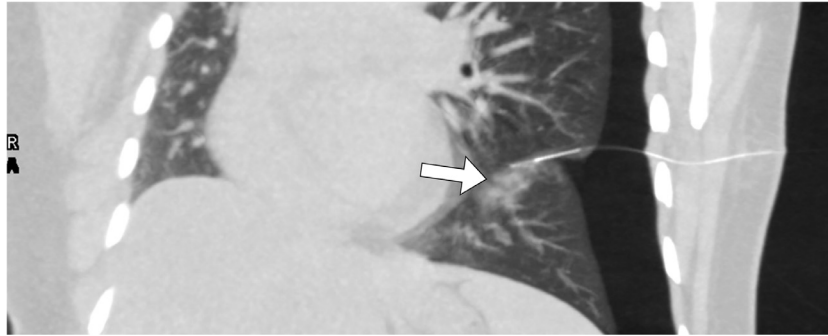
Chest CT scan in sagittal section showing pneumothorax after placement of the harpoon in the pulmonary nodule described.
